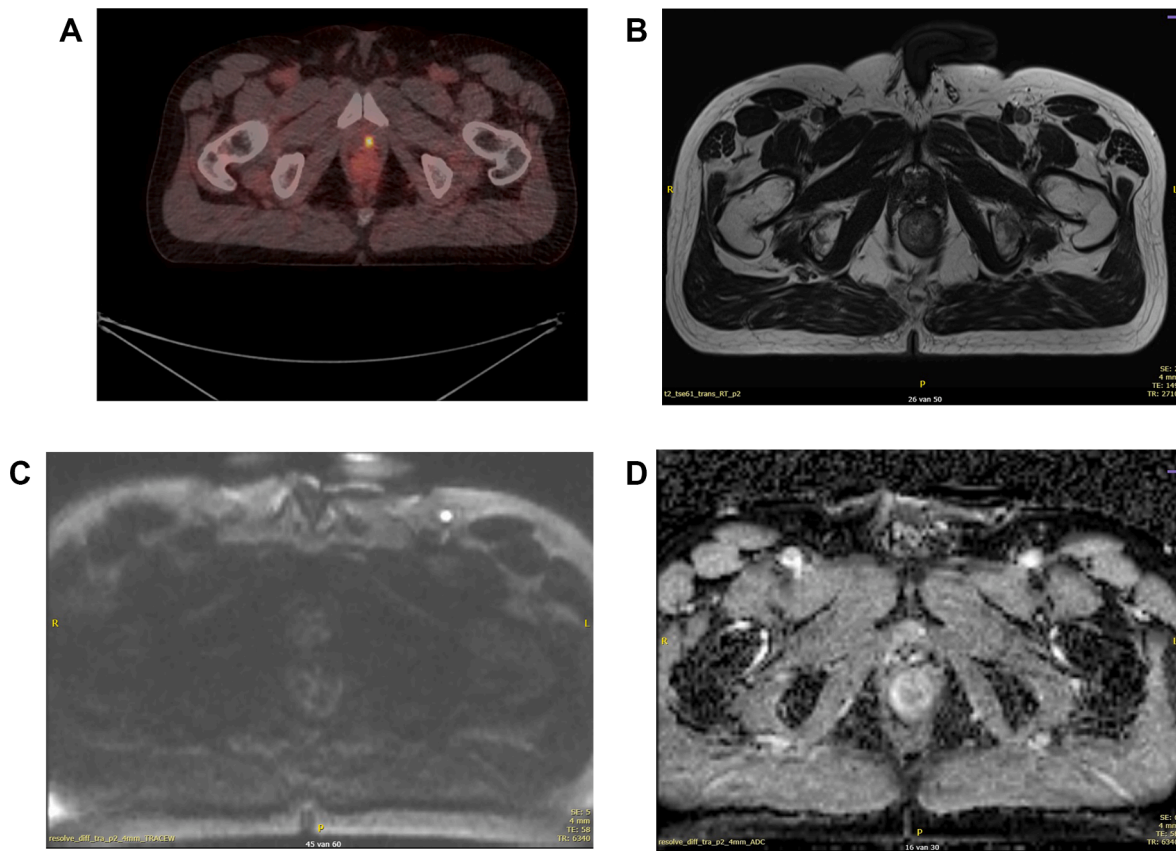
Suspect lesion to the left of the anastomosis (case 2). Images provided by GZA Hospitals, Department of Radiation Oncology. 2A. ⁶⁸PSMA-PET image. 2B. MRI T2-weighted image. 2C. MRI diffusion-weighted (DW) image. 2D. MRI apparent diffusion coefficient (ADC) map.
